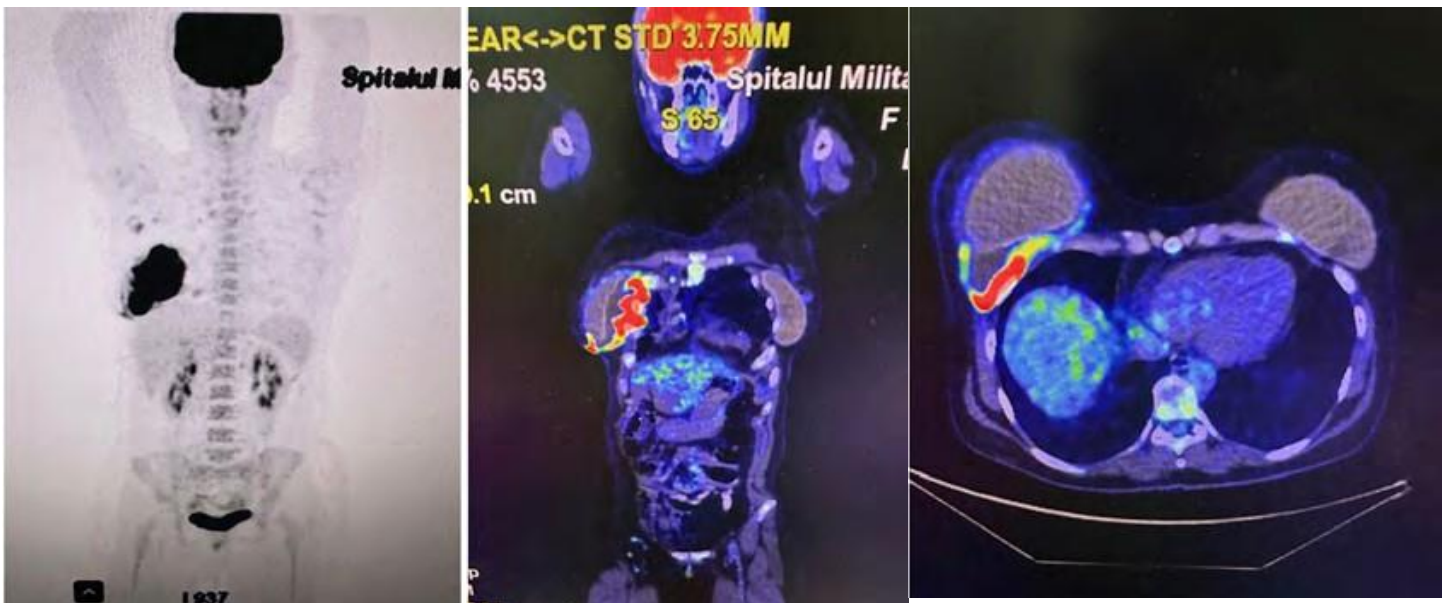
Active metabolic changes located around prosthetic implant in the right breast on PET/CT.
